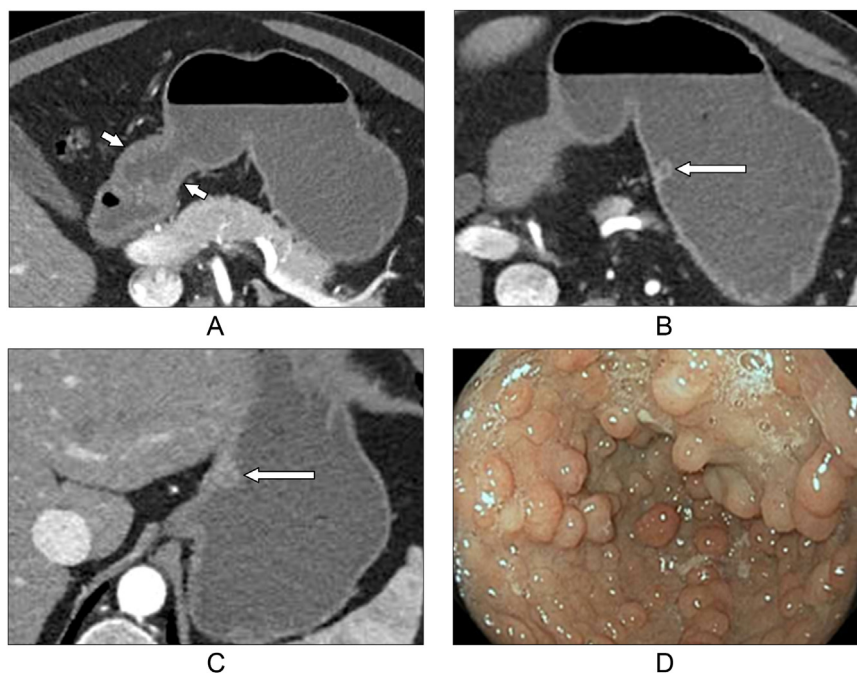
Forty- two year-old man with history of eosinophilic esophagitis and eosinophilic gastritis. (A) Axial contrast-enhanced CT image shows mucosal thickening and nodularity of the gastric antrum (small arrows). (B, C) Note the 2 benign-appearing inflammatory proximal gastric polyps (confirmed on biopsy) (larger arrows). (D) Endoscopic image shows eosinophilic gastritis with nodularity of the antrum from polyps in another patient (Color version of figure is available online.)
